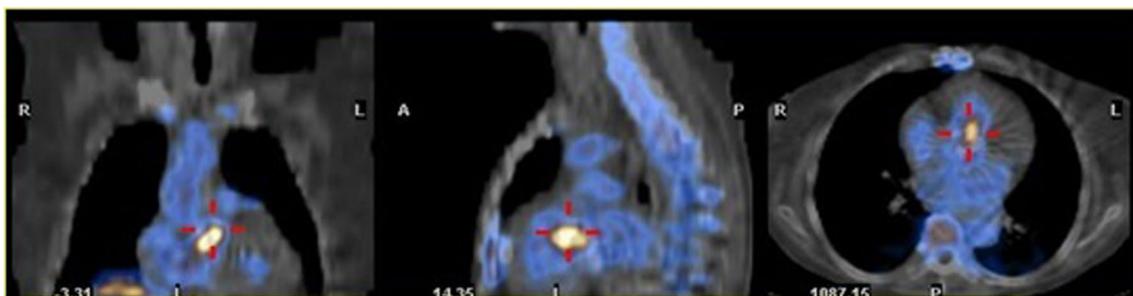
^{99m}Tc -HMPAO WBC SPECT/CT imaging in a patient with PVE. The emission image (*middle*) shows an area of increased radiopharmaceutical uptake which on the superimposed SPECT/CT image (*bottom*) corresponds to the prosthetic aortic valve. *Top* low-dose CT image
